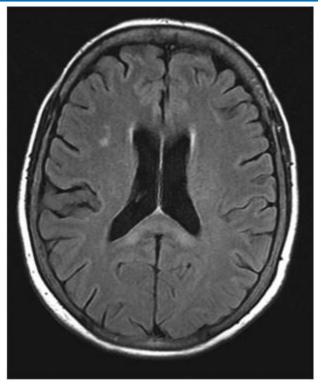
MRI brain with Gadolinium contrast
